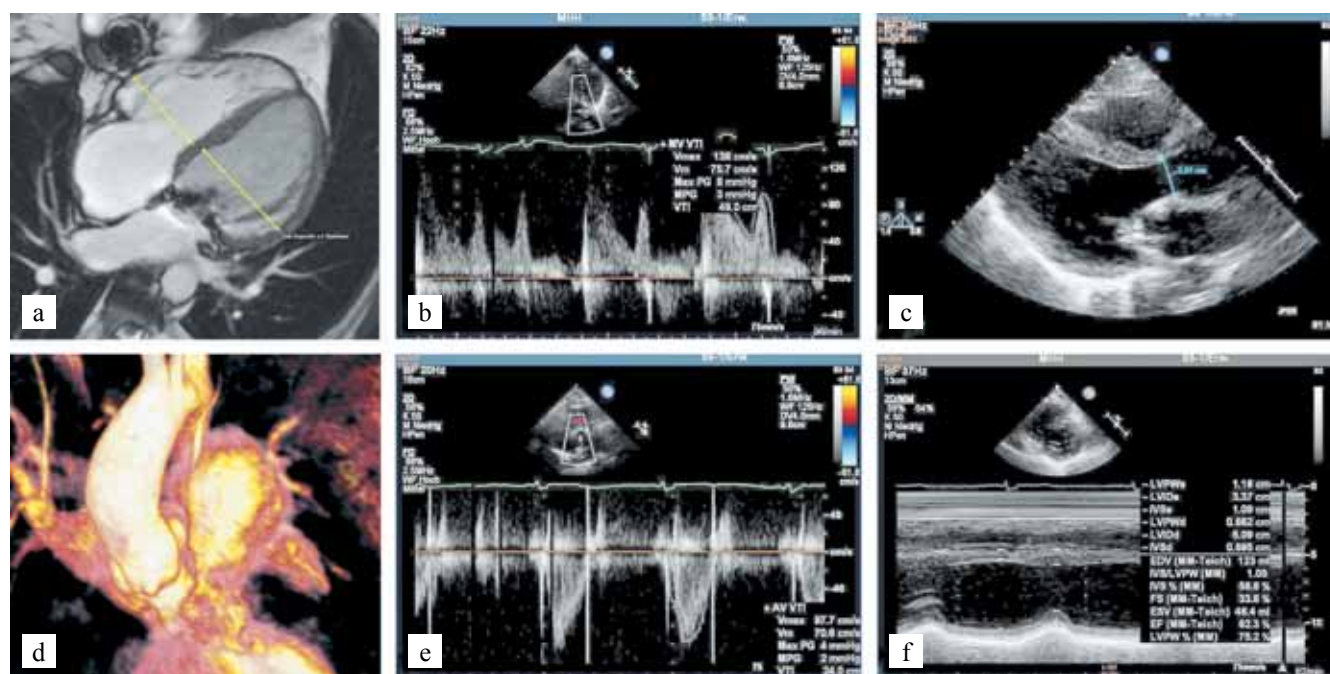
Postoperative findings: a – four chamber view showing normal heart dimensions; b – pw-Doppler signal in reconstructed mitral valve; c – B-mode systolic longitudinal axis showing wide LVOT and good mitral coaptation; d – contrast enhanced MRI-angiography of LVOT; e – pw-Doppler signal in aortic annulus; f – M-Mode dimensions of the LV
